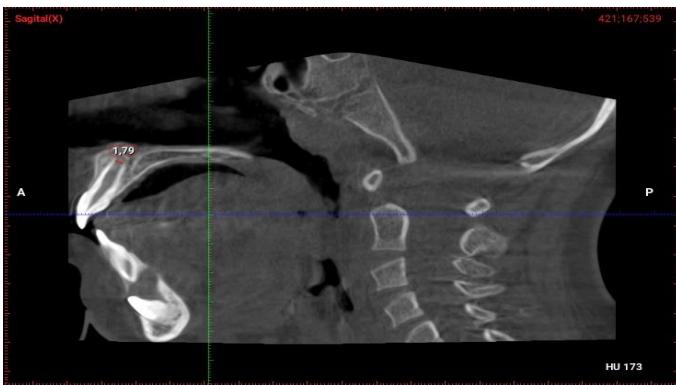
Measurement of the distance of the maxillary anterior teeth to the floor of the nasal cavity in the sagittal plane on CBCT.
